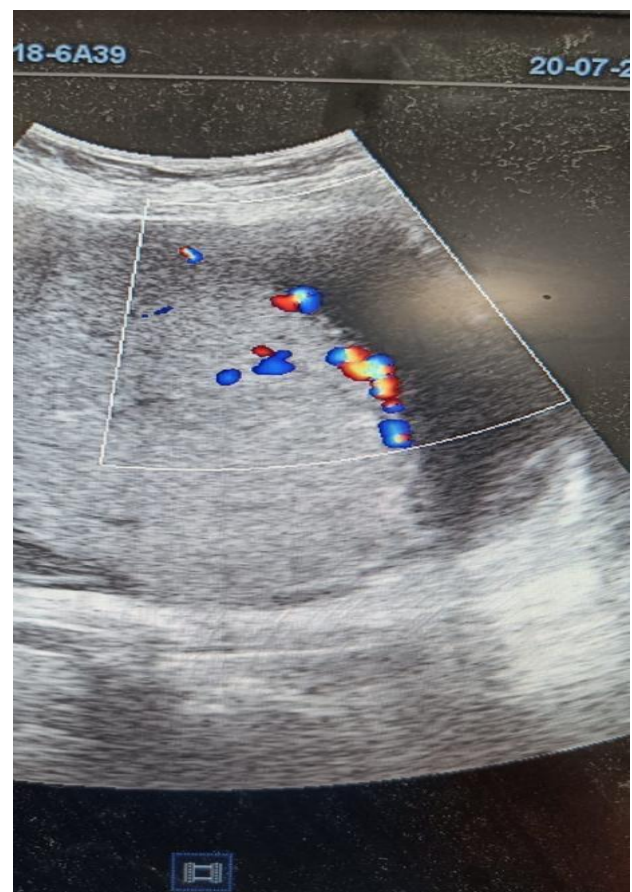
Antenatal ultrasonography showing anterior lying placenta completely covering the internal OS.
